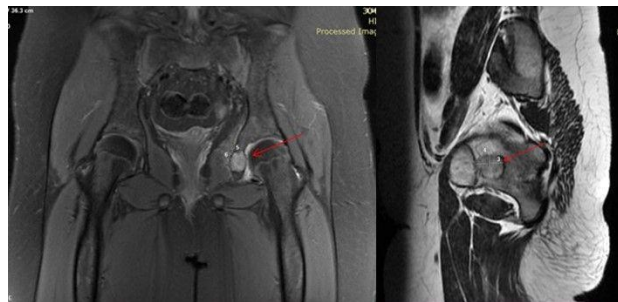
MRI showing a T2 hyperintense and T1 hypointense lesion in the region of the left acetabulum.
